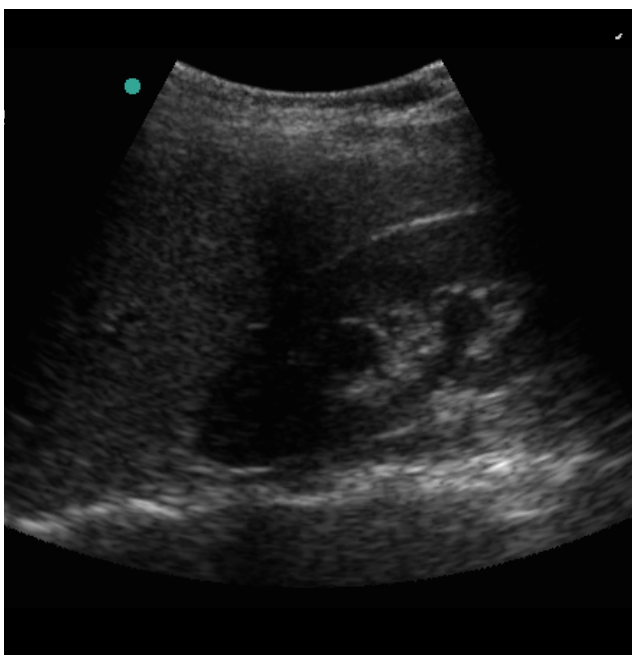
Ultrasound at 24-week intrauterine pregnancy.
